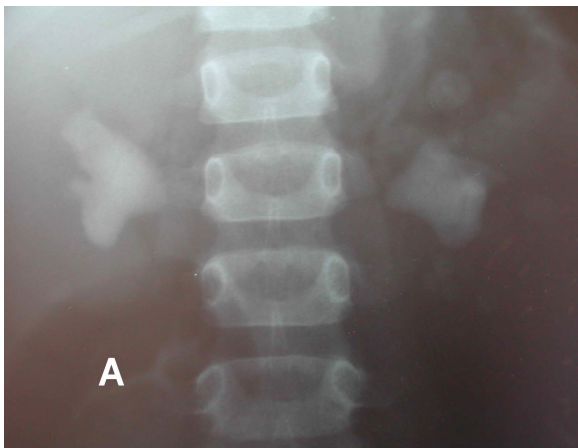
A, B. The appearance of the x-ray and stones cases in the first patient.
